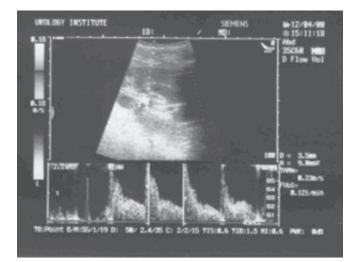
Doppler curve under vesicoureteral reflux of the 1st degree.
